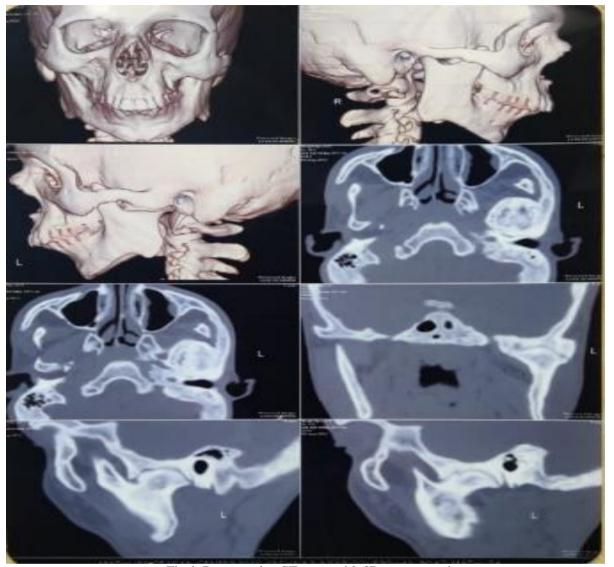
Preoperative CT scans with 3D reconstruction
